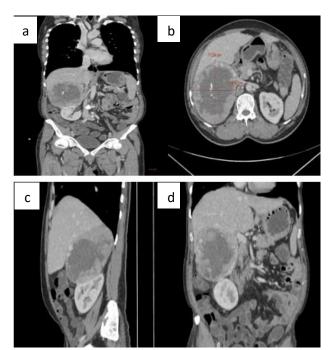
(a-d): CT images showing right sided adrenocortical mass.
